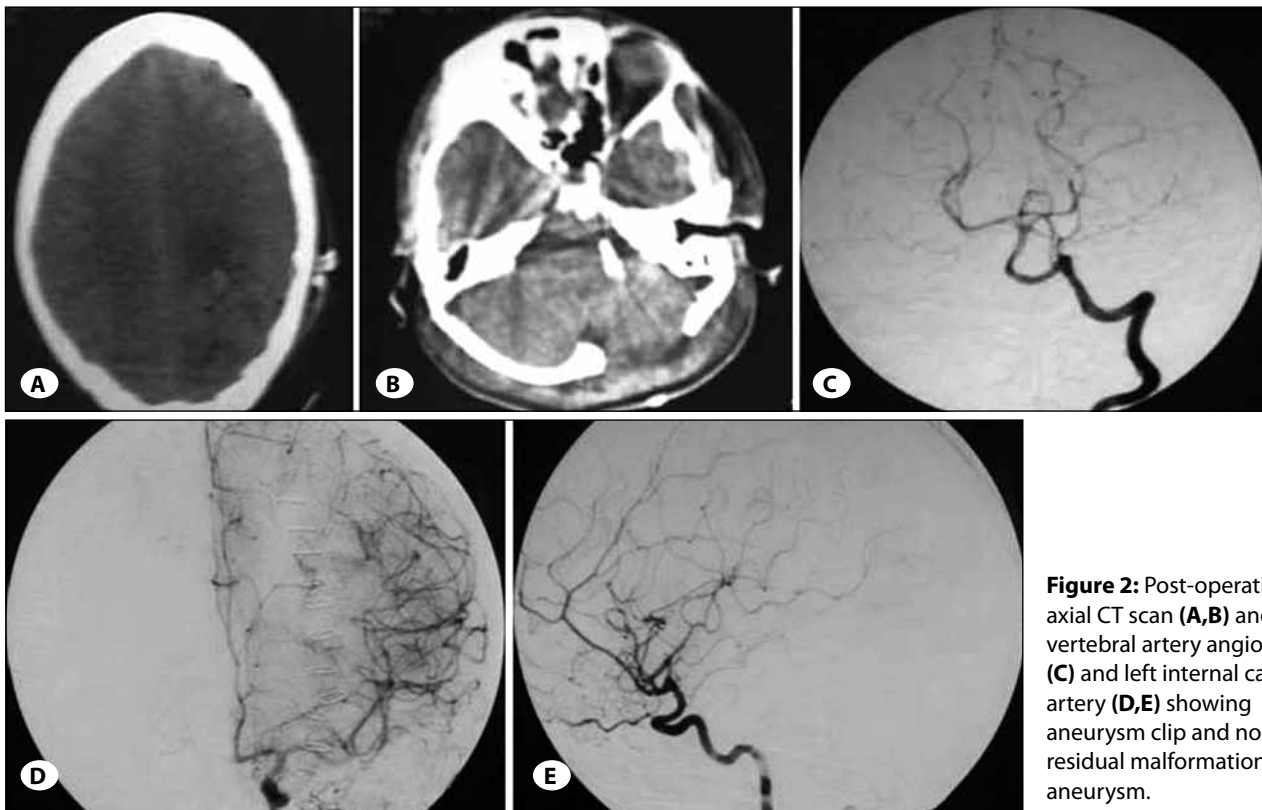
Post-operative axial CT scan (A,B) and left vertebral artery angiograms (C) and left internal carotid artery (D,E) showing aneurysm clip and no residual malformation and aneurysm.
